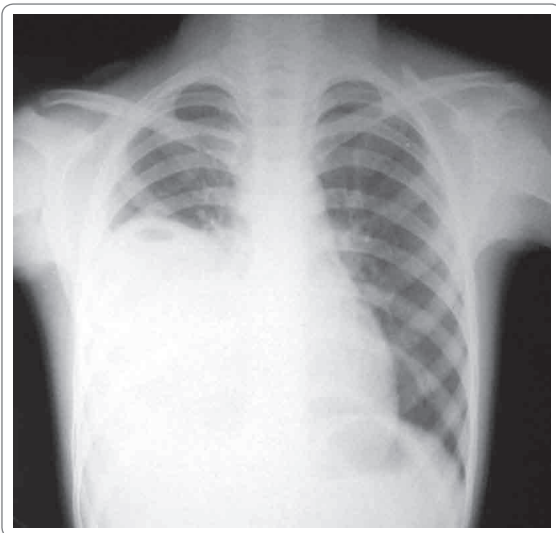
Chest X-ray shows homogenous radio-opaque opacity involving right lower lung with costophrenic angle (Courtesy: Dr. Soma Sarkar)
